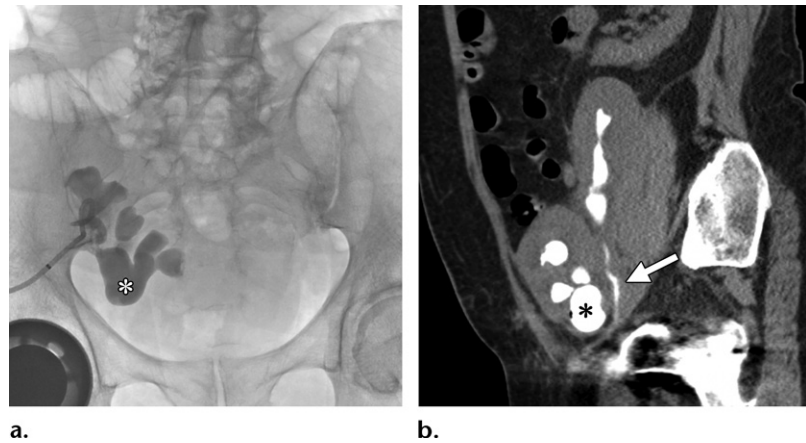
Ureteropelvic junction (UPJ) obstruction due to desmoplastic reaction, scar tissue, and kinking at the UPJ of the lower moiety in a patient with en bloc adult deceased donor kidney transplant in the right lower quadrant. (a) Fluoroscopic image obtained during antegrade pyelography of the lower transplant kidney shows severe pelvicaliectasis (*) without opacification of the urinary bladder, consistent with UPJ obstruction. (b) Subsequent sagittal nonenhanced CT image after antegrade injection of contrast material into the collecting systems shows persistent pelvicaliectasis of the lower moiety (*) and visualization of only the normal-caliber upper moiety transplant ureter (arrow). Pyelovesicostomy of the inferior allograft with bladder flap and hitch was performed (not shown), with resolution of the hydronephrosis.
